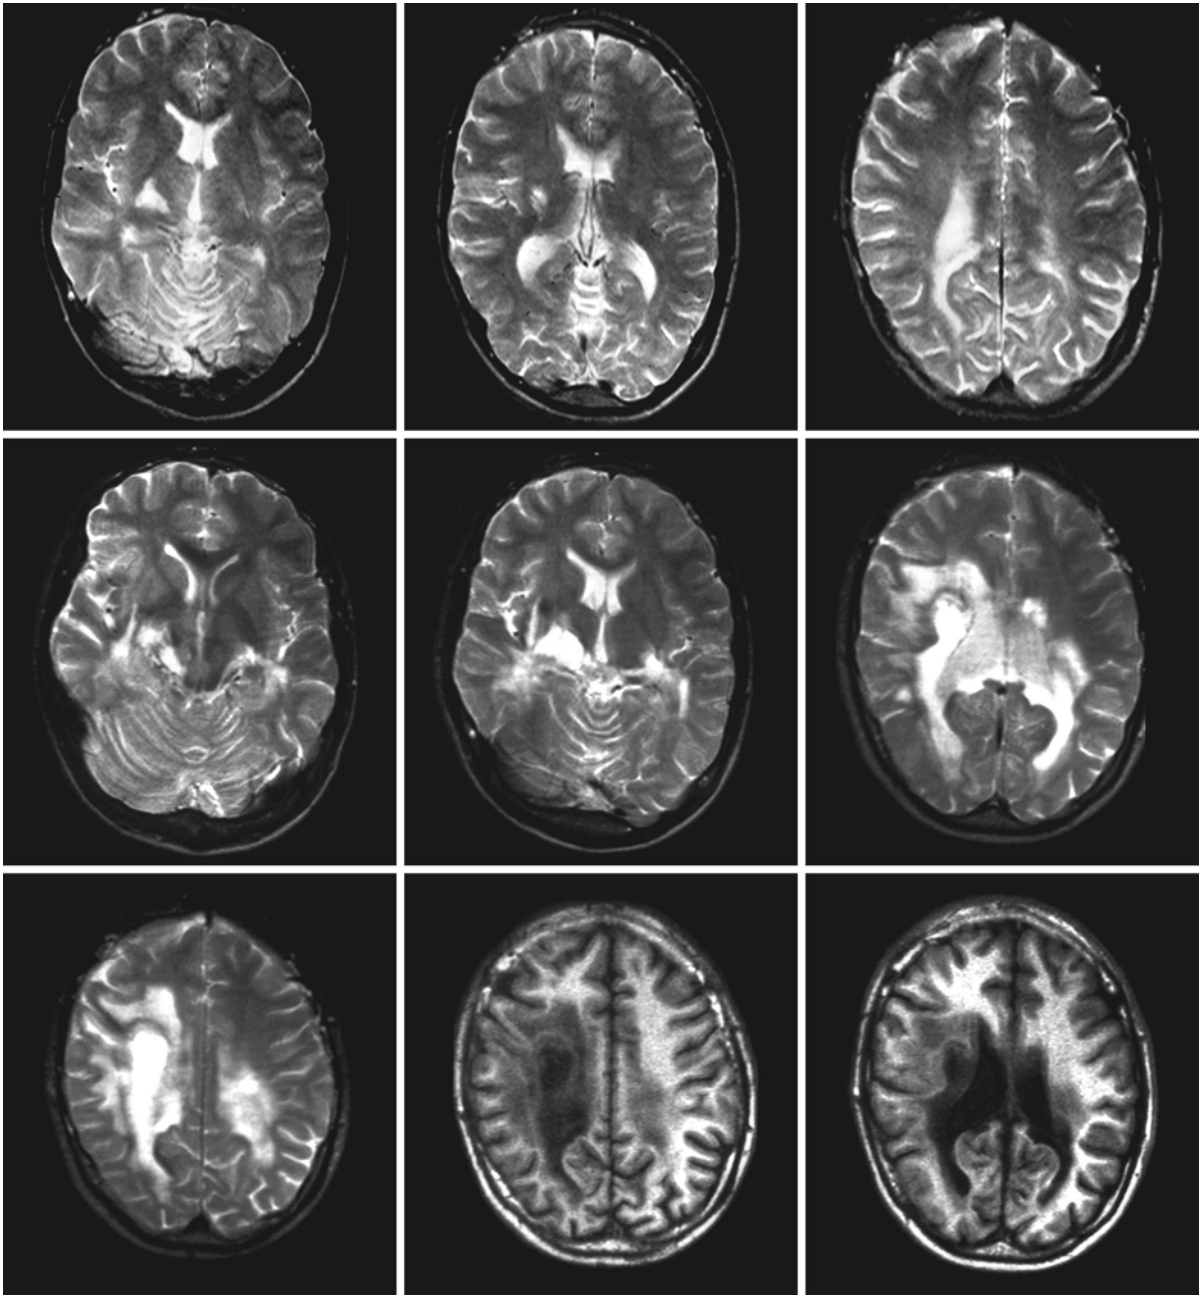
Adult male patient with cerebral XALD. The MRI of the *first row* was obtained when he was 29 years old; the MRI of the *second and third rows* when he was 31 years old. The process started unilaterally and progressed to a bilateral but highly asymmetrical disease with predominant involvement
